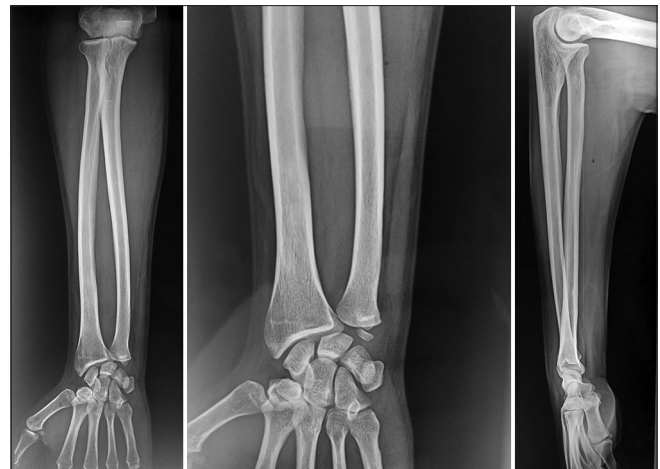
Postreduction X-rays of the arm and wrist
